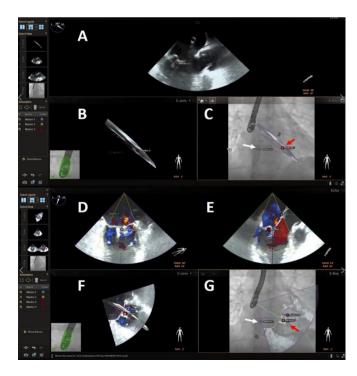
Fusion image of echocardiography and fluoroscopy, facilitating the procedural guidance during the MitraClip procedure. Panel a demonstrates real-time transesophageal image during the procedure whereas panel b shows the spatial orientation of that two-dimensional view based on the fluoroscopic projection. The probe is detected indicating that the position of the probe relative to the C-arm has been detected leading to the overlaid of the transesophageal echocardiographic view
